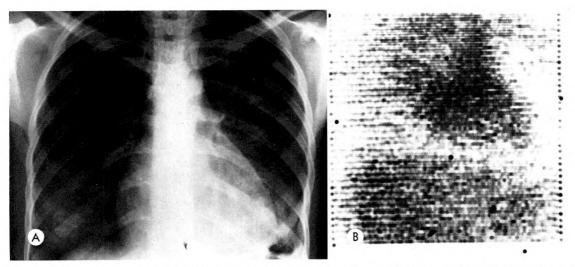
(A) Six foot, posteroanterior, erect chest roentgenogram of a 22 year old woman who had received a gunshot wound of the left posterior chest wall 2 weeks before this study was made. Progressive enlargement of the cardiac silhouette had been observed. Note retained bullet fragment to the left of the centrum of the 11th thoracic vertebra. (B) Photoscan made with 1.6 mc Tc99m HSA tracer shows evidence of belt phenomenon along the left side of, and inferior to, a small blood pool. Pericardiocentesis yielded 180 ml. of blood-tinged fluid. This may have been the approximate volume of the effusion.
